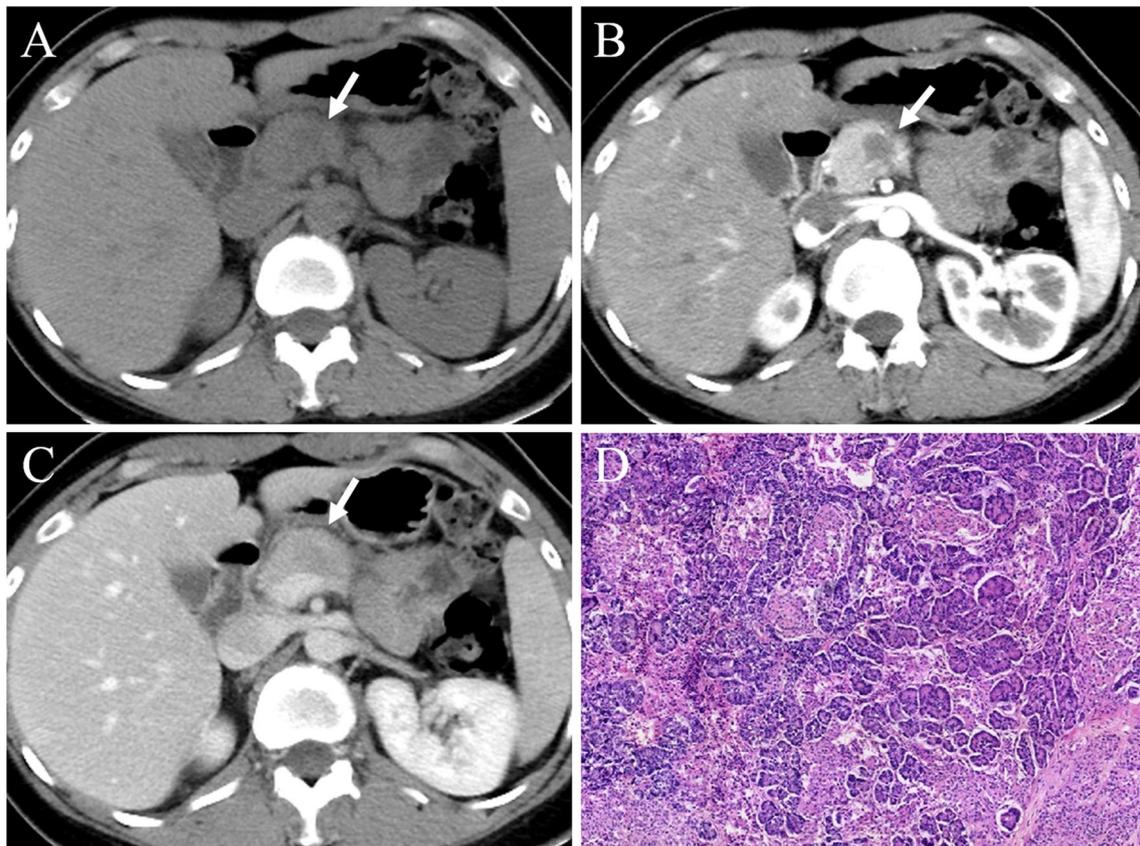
A 47-year-old man with a 1.2-cm purely solid, aggressive SPN of pancreas. Axial unenhanced scan (a) shows a slightly hypoattenuating lesion (arrow) in body of pancreas. Arterial phase (b) CT image shows ill-defined hypoattenuating lesion compared with the adjacent
